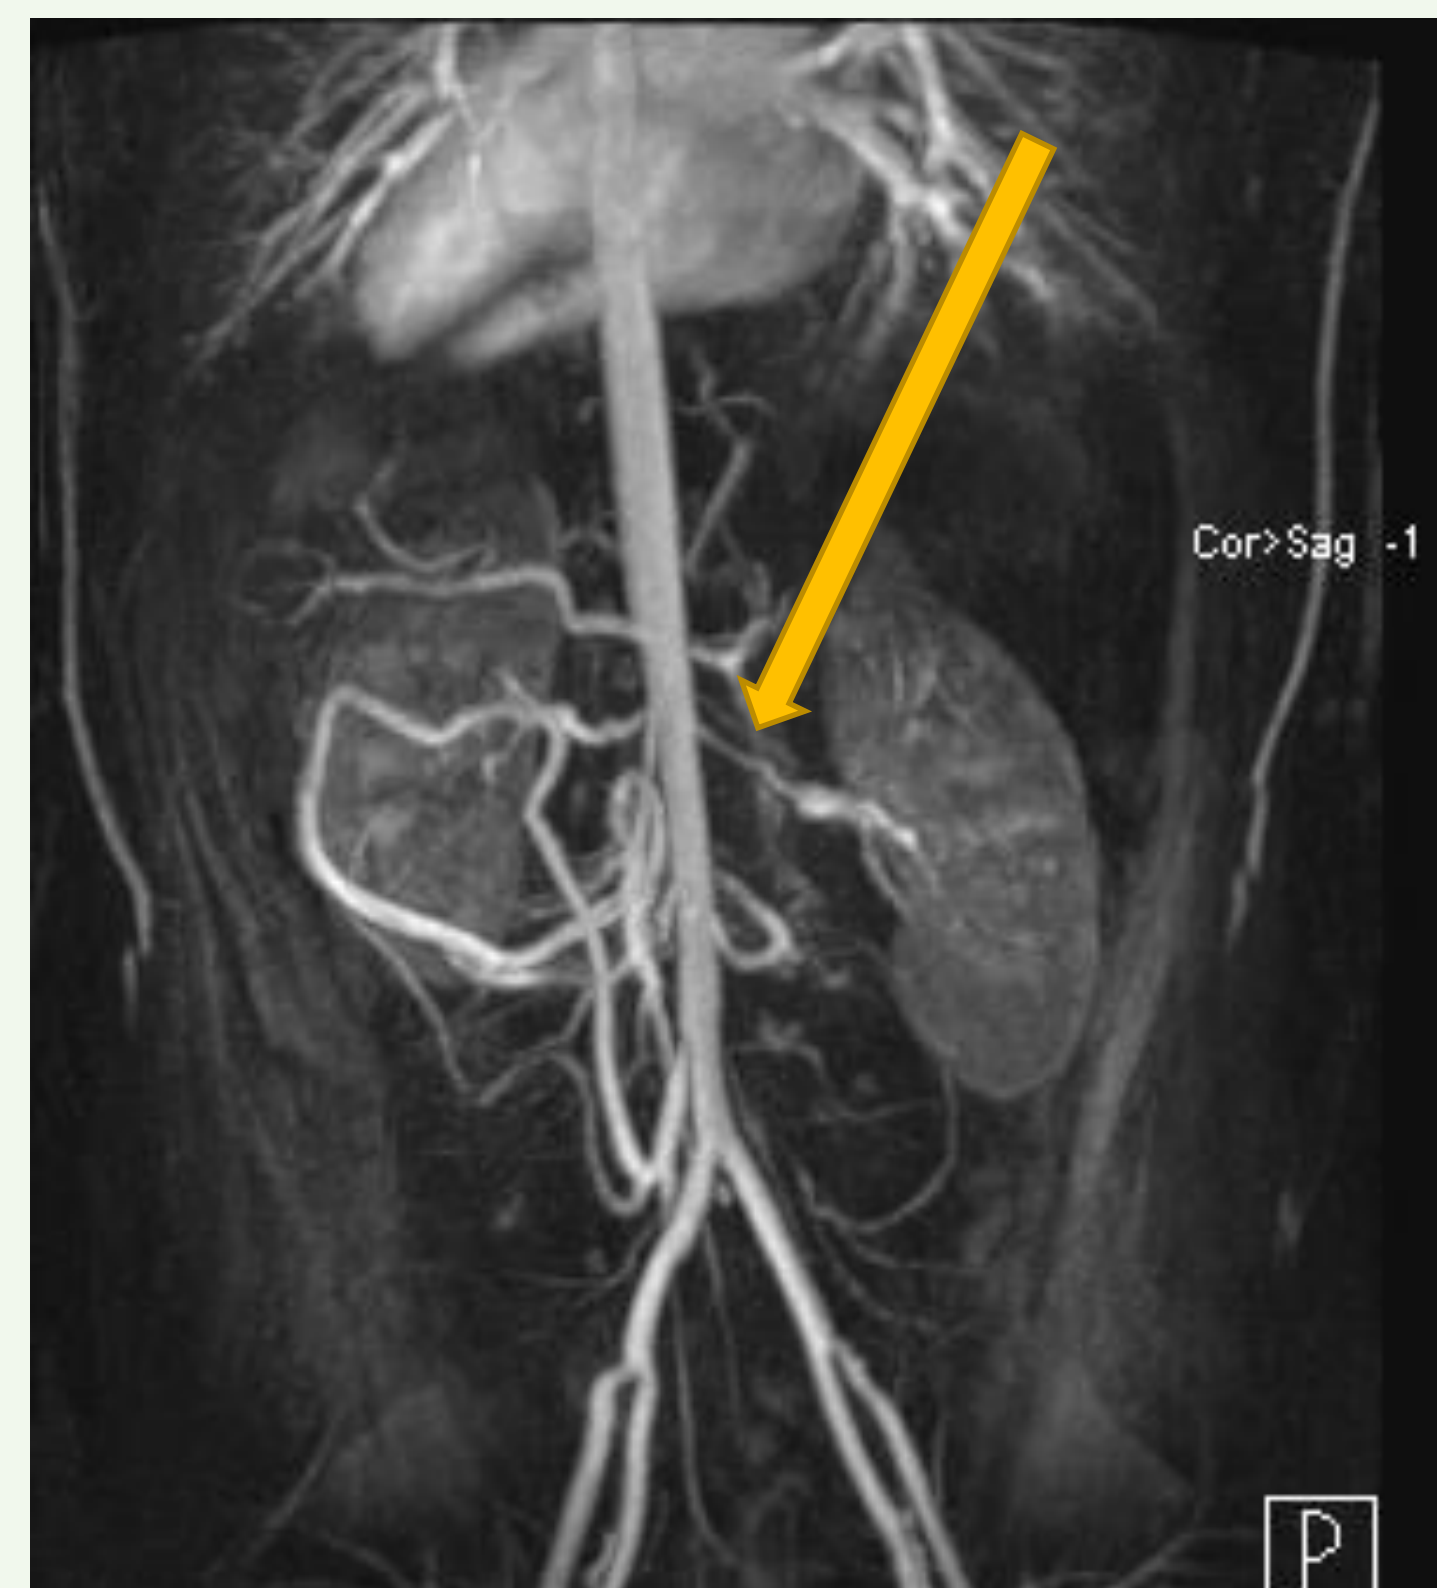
At 12 years old, CT Angiogram demonstrates severe stenosis of the origins of the major branches of the aorta including the celiac artery, SMA, renal arteries, and IMA.
